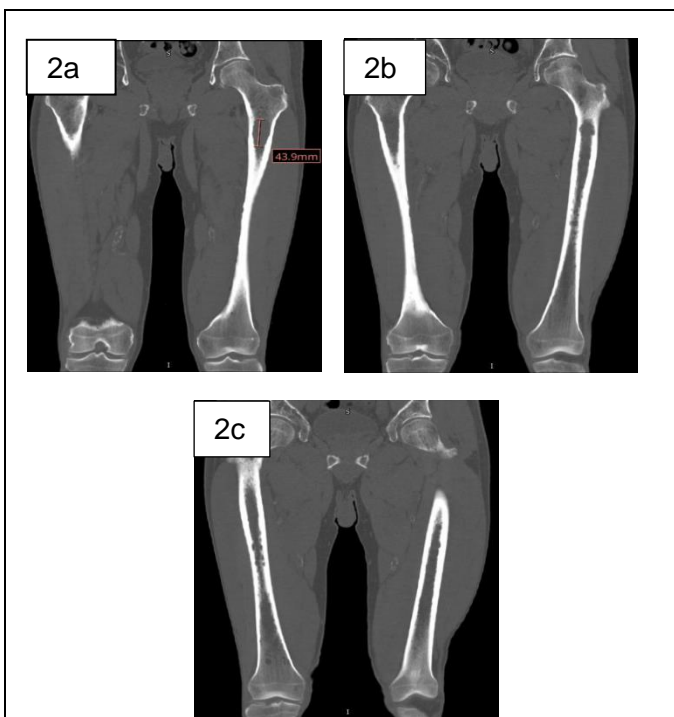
CT scans of the bilateral femurs taken one month after initial diagnosis. The demonstrated lesions are centrally located and lack substantial cortical involvement even though they occupy
